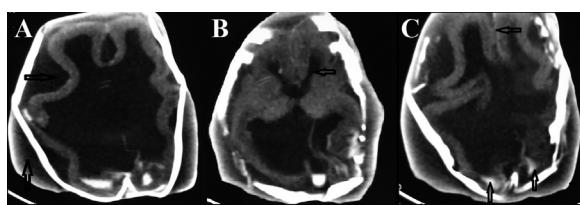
(A) Axial computed tomography image showing dysmorphic monoventricle, extra-axial and extracranial cerebrospinal fluid collection (marked with arrows) and CSF collection within the frontal interhemispheric fissure. (B) Axial computed tomography image from lateral ventricle level demonstrates well differentiated frontal horns of the lateral ventricle (marked with arrow), dilated occipital horns (especially the right horn) and fragmented skull bones. (C) Axial computed tomography image showing frontal interhemispheric fissure (marked by horizontal arrow) and intraventricular hemorrhage in the posterior aspect of the monoventricle (marked by two vertical arrows).
